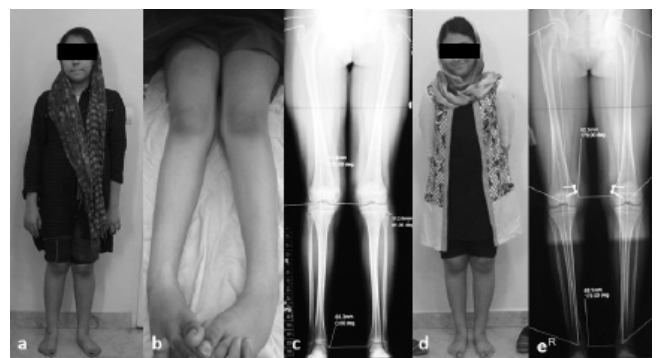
(a and b) Standing and supine picture of genu valgum in a 12-year-old girl, (c) Her standing lower limbs film. (d, e) She was operated using X-plate on both sides; her standing picture and X-rays; after a one-year follow-up, her plate has been removed.
